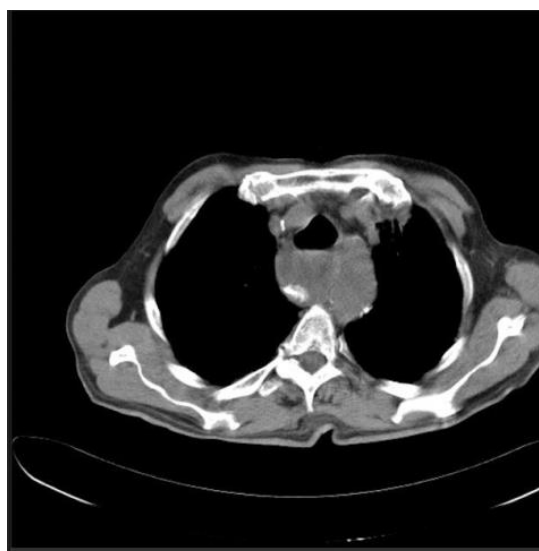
Zenker's diverticulum from the same patient is shown using computed tomography.
